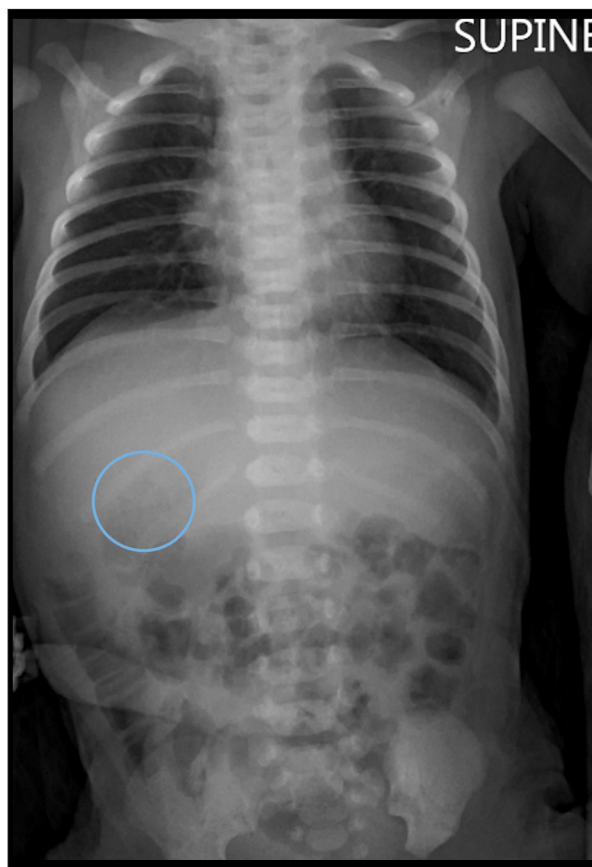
Chest and abdominal radiograph showing gastric bubble in the right hypochondrium (blue circle). There are no dilated bowel loops.
